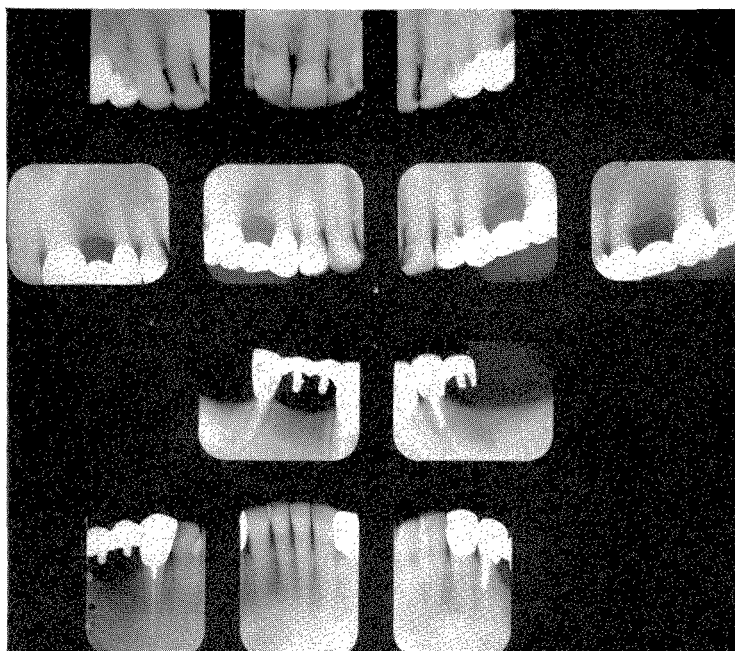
Roentgenograms taken in 1958 after the removal of the lower right first molar distal root and the insertion of the new bridge. Also, the lower left second bicuspid was lost, and a new cantilever was inserted.
